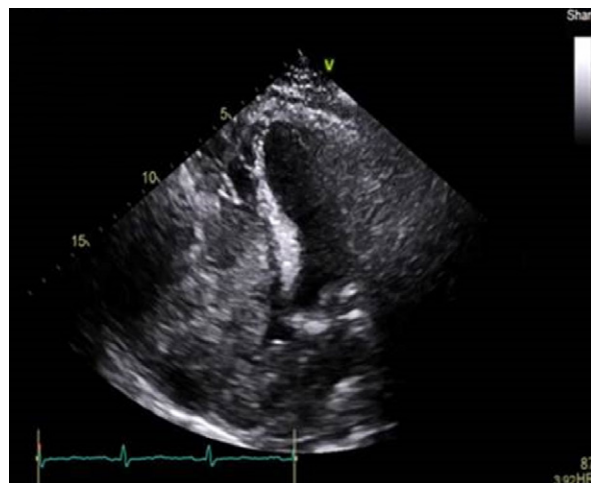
Transthoracic echocardiogram shows a large heterogeneous mass occupying the right atrium and right ventricle, with obstruction at the level of the tricuspid valve.
